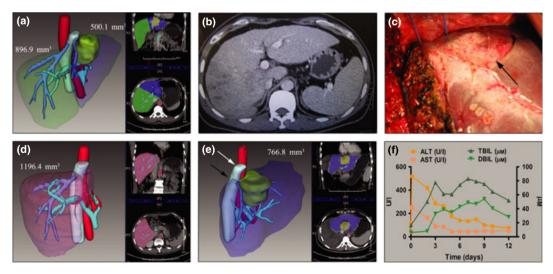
(a) Re-evaluated CT image of cavernous hemangioma in the donor. (b) CT showing a giant lesion in the right lobe of liver in the recipient. (c) Intraoperative view of cavernous hemangioma (black arrow). (d) Re-evaluated 11-day postoperative CT image of the remnant liver of the hemagioma patient. (e) Re-evaluated 11-day postoperative CT of the graft in the recipient (white arrow indicates the original outflow site of hepatic vein; black arrow the modified one). (f) The recipient's liver function curve during 12 days after transplant.
